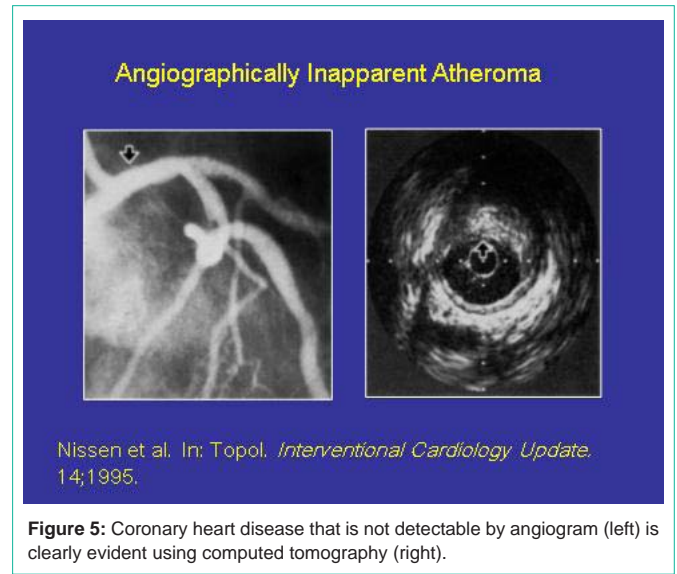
Coronary heart disease that is not detectable by angiogram (left) is clearly evident using computed tomography (right).
